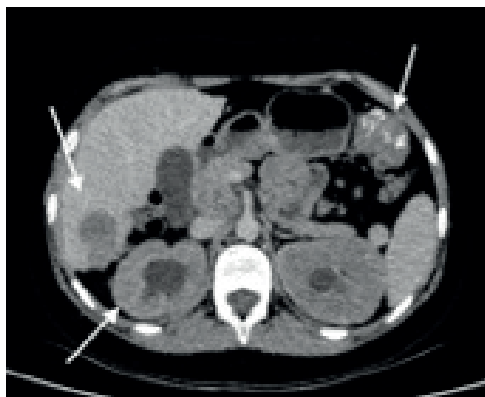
CT image demonstrating multiple abdominal, pelvic, liver masses (Patient 2)
